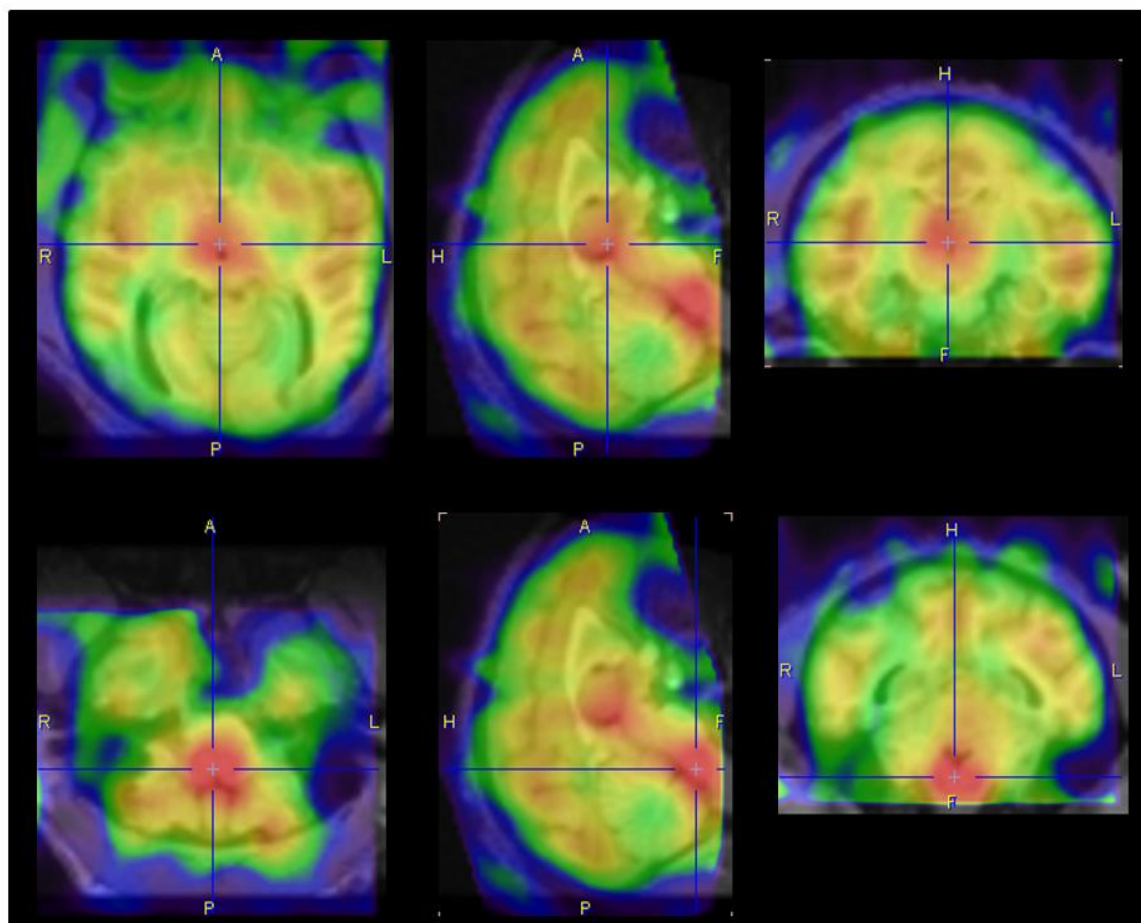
MRI co-registered SPECT images of ^{123}I -INER distribution in baboon brain at baseline.
